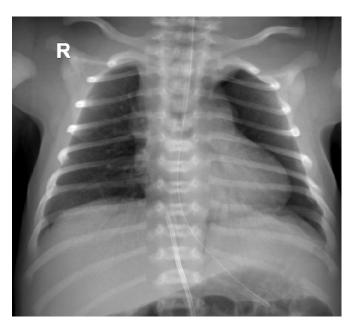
Chest radiography: left apical pneumothorax and grade II RDS.
